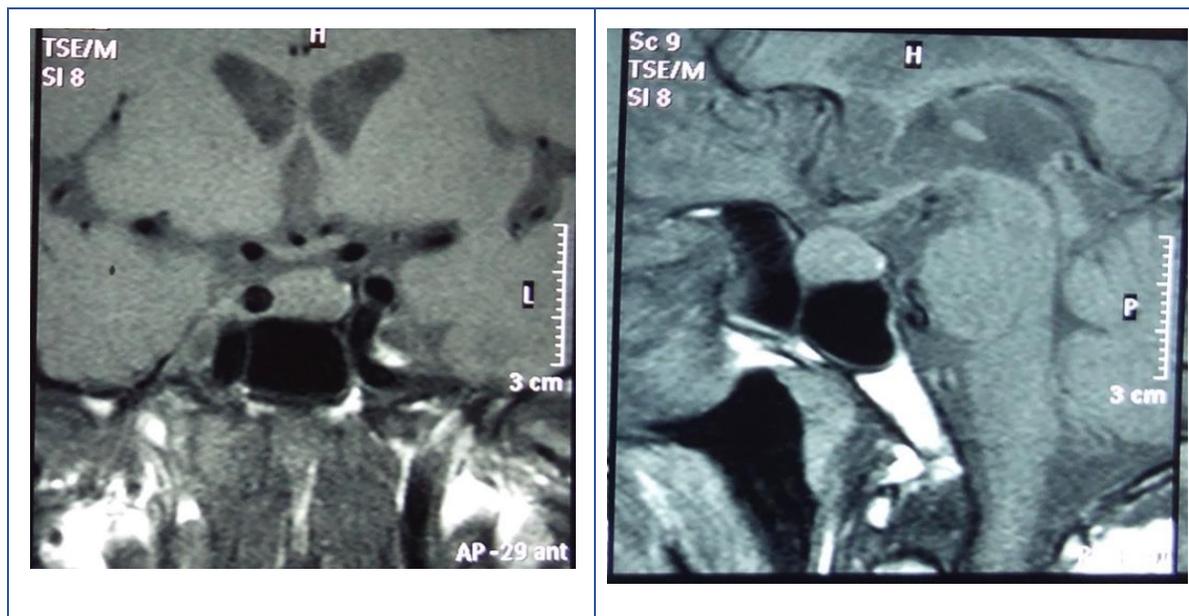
Initial MRI brain T1 weighted non contrast enhanced-Pituitary gland enlarged with convex sella turcica measuring 14\*14.1\*14.2. There is a hypointense non enhancing intrasellar lesion with peripheral ring enhancement compressing the pituitary parenchyma.
